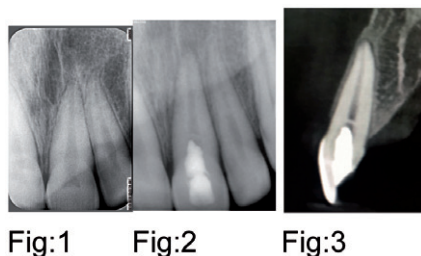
X-Ray of tooth 21 before revascularization/revitalization.
